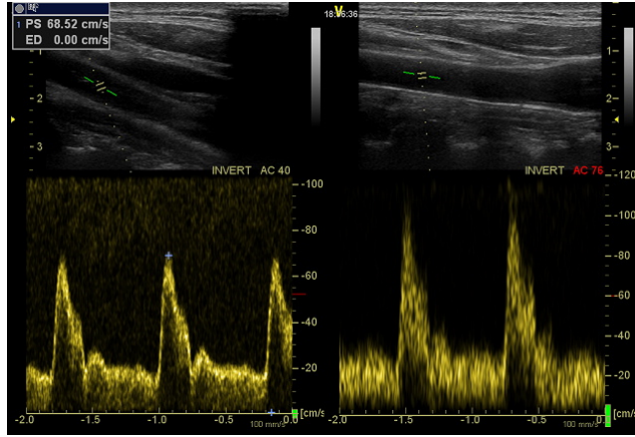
The effect of beam-to-flow angle on PW-Doppler. The spectrogram on the left is generated with a small beam-to-flow angle while the right one is estimated with the data recorded with a large beam-to-flow angle. Large beam-to-flow angles result in increased spectral broadening and potentially overestimation of maximum blood velocities.
